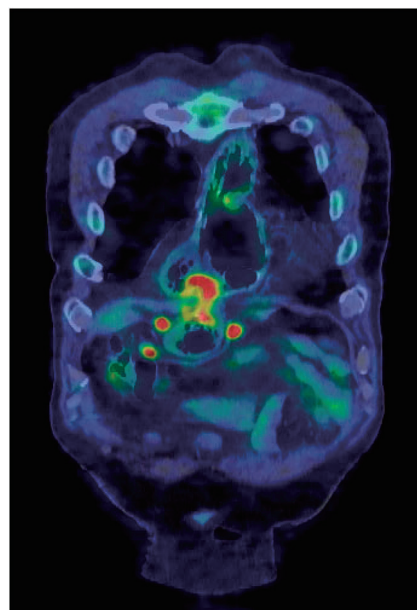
FDG PET-CT image. FDG PET-CT shows FDG accumulation in the tumor at the antrum and lymph nodes (right gastroepiploic and supra- and infrapyloric lymph nodes). FDG PET-CT: fluorodeoxyglucose positron emission tomography-computed tomography
